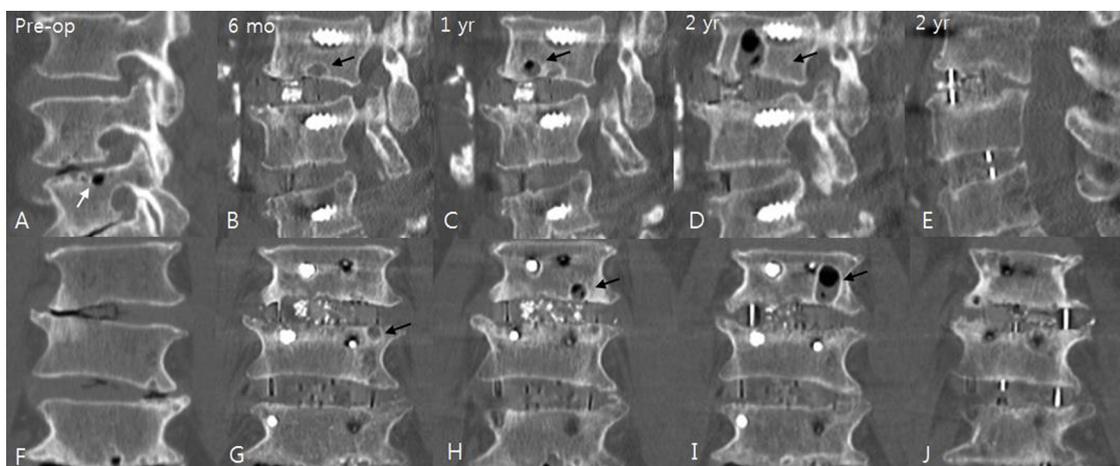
A 71-year-old male who underwent oblique lumbar interbody fusion at L3-4 and L4-5 levels. Typical cystic changes in computed tomographic sagittal and coronal images before surgery and at 6-month, 1-year, and 2-year after surgery (A to D and F to I). Black arrows demonstrate endplate cyst becomes larger identified as positive cyst sign in superior level (L3-4). White arrow demonstrates endplate cyst becomes smaller then disappears which is identified as negative cyst sign in inferior level (L4-5). Typical radiologic fusion with bone union is shown in sagittal (E) and coronal (J) images at 2 years after surgery.
